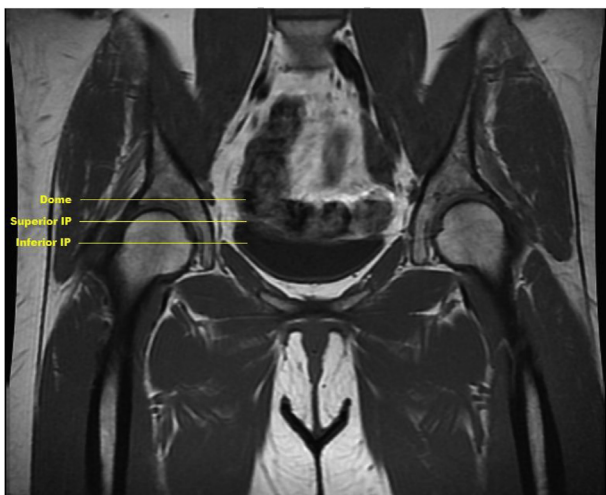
Coronal MRI of the hip demonstrating the locations of the three axial cuts utilized for the examination of the femoral neurovascular bundle; these levels included the acetabular dome, superior iliopectineal ridge and the inferior iliopectineal ridge.
